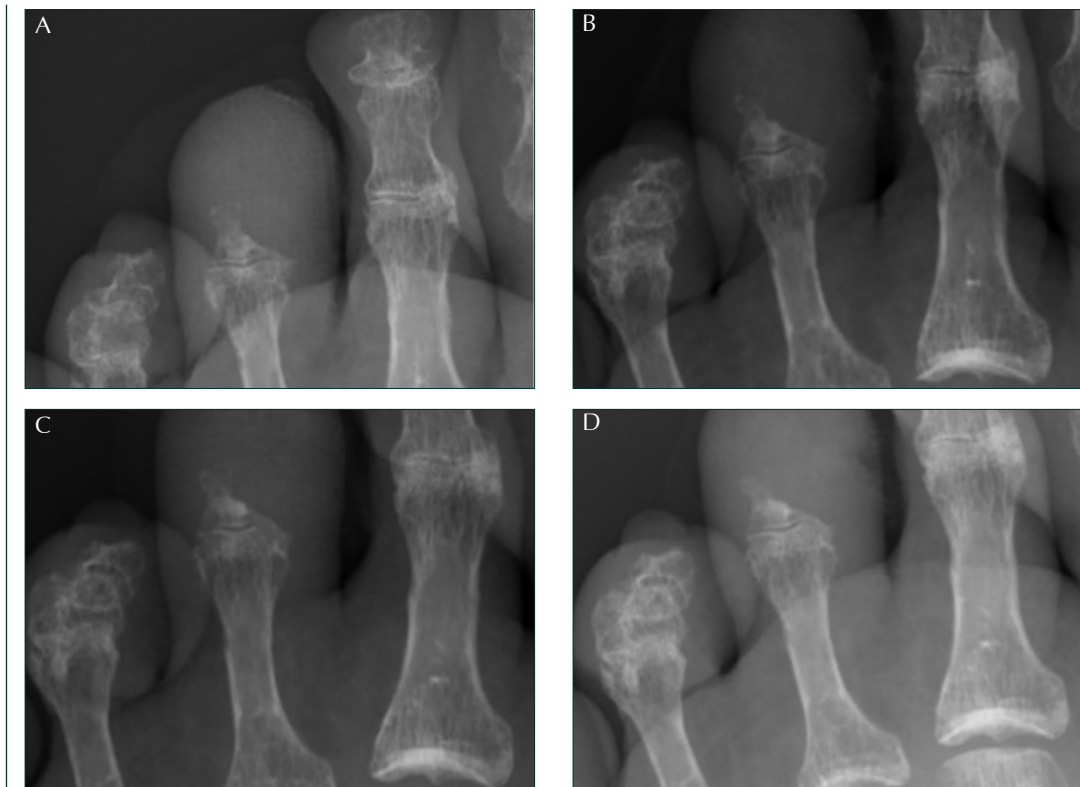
A: X-ray on August 6, 2021. B: August 27. C: September 27. D: October 8.
